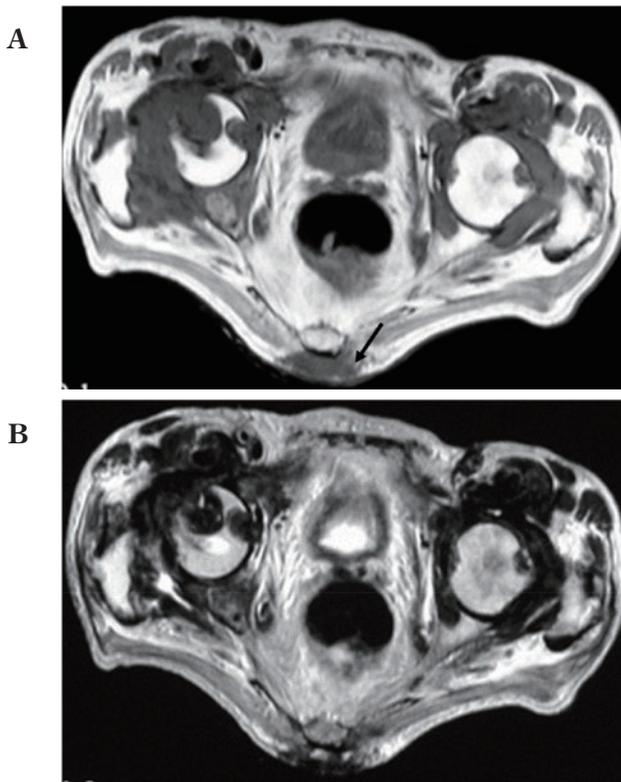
Axial MR images at the level of the femoral heads.
